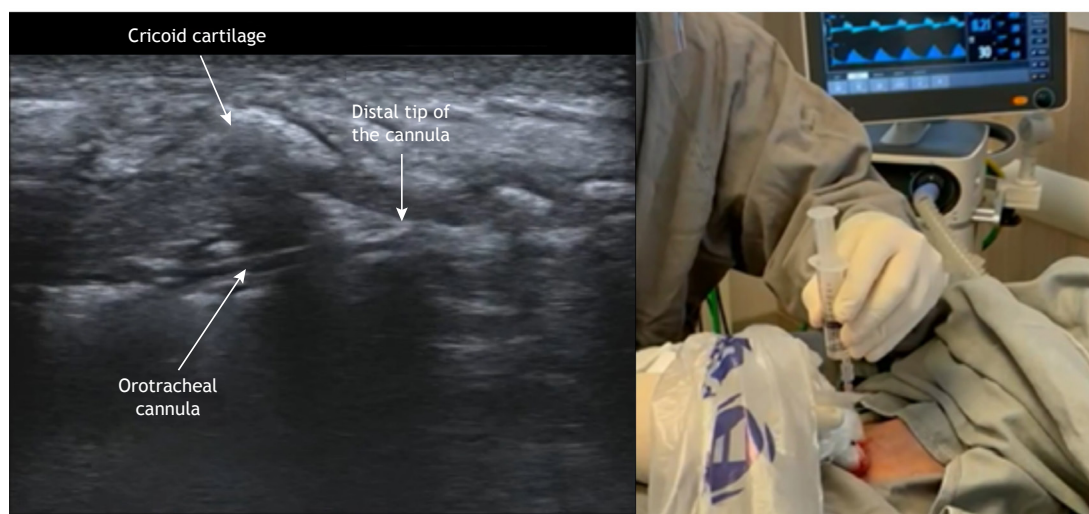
Percutaneous tracheostomy. a) Sagittal view of the trachea showing the orotracheal cannula represented by a double hyperechoic line with acoustic shadowing. The tip of the endotracheal tube is ideally positioned under the first tracheal ring to ensure a clear path for the tracheal puncture while reducing the risk of accidental extubation. b) Repositioning of the endotracheal tube prior to midline perpendicular tracheal puncture is performed under ultrasound guidance, thus reducing the risk of complications. The patient should be placed in the supine position.
